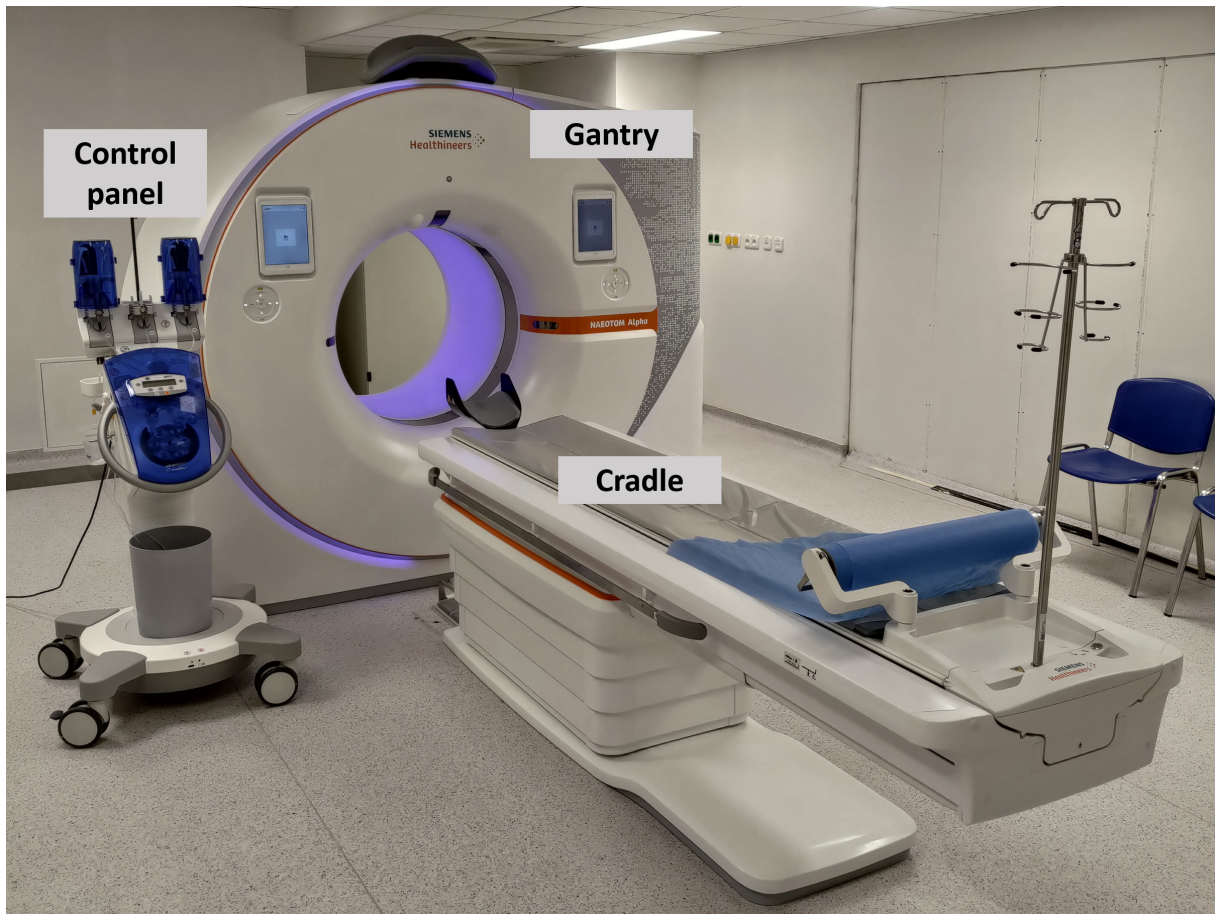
Modern CT scanner located at the Lochotín University Hospital in Pilsen, Czech Republic (Siemens NAEOTOM Alpha) [1].
